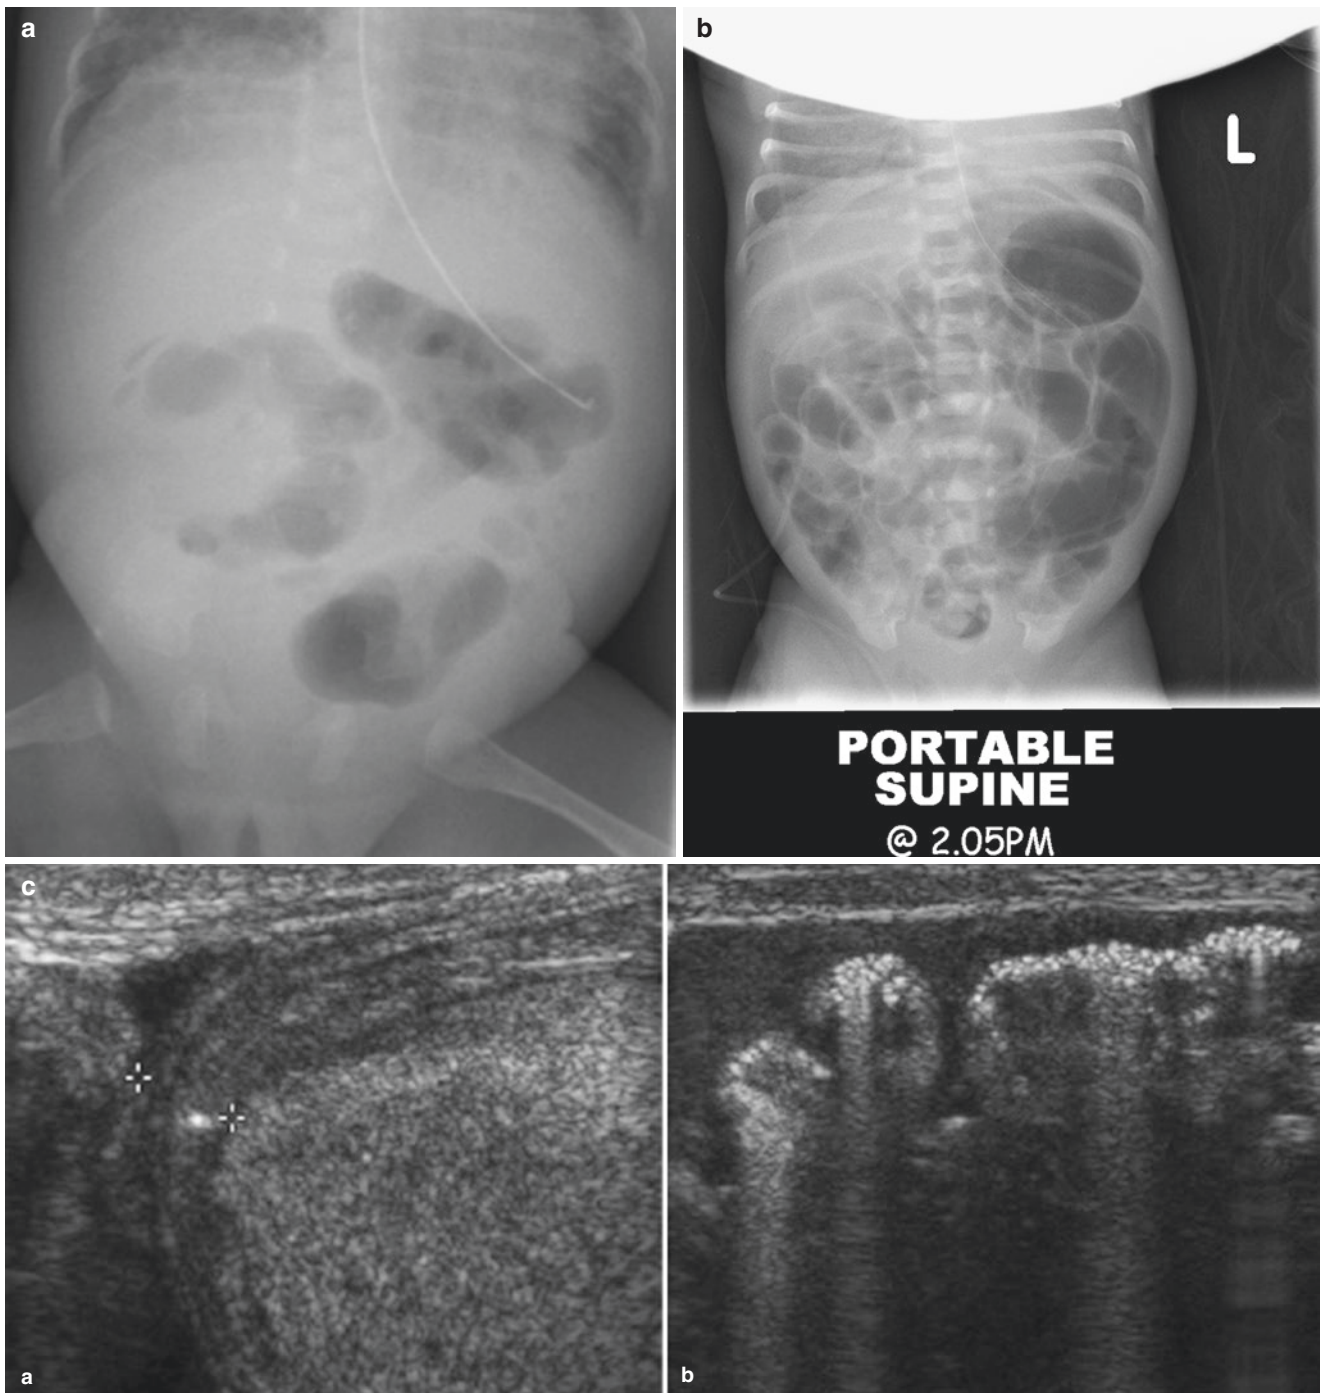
(a) Plain X-ray of the abdomen of a premature baby with severe necrotizing enterocolitis. (b) Necrotising enterocolitis. Plain X-ray showing pneumatosis and perforation, free gas. (c) Ultrasound showing thickened loops of intestine with intramural gas and free fluid. (d) Plain X-ray of the abdomen in a premature baby with necrotizing enterocolitis and pneumatosis intestinalis. Note the gas in the area of the liver indicating portal venous gas. (e) Barium study in necrotizing
